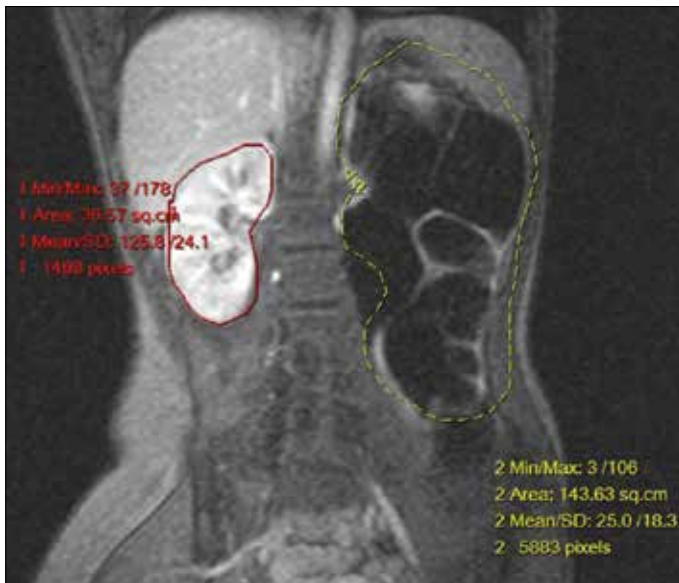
Dynamic contrast-enhanced MRI in a 14-year-old female. MR renogram images showing left PUJO with gross hydronephrosis and significantly thinned renal parenchyma
